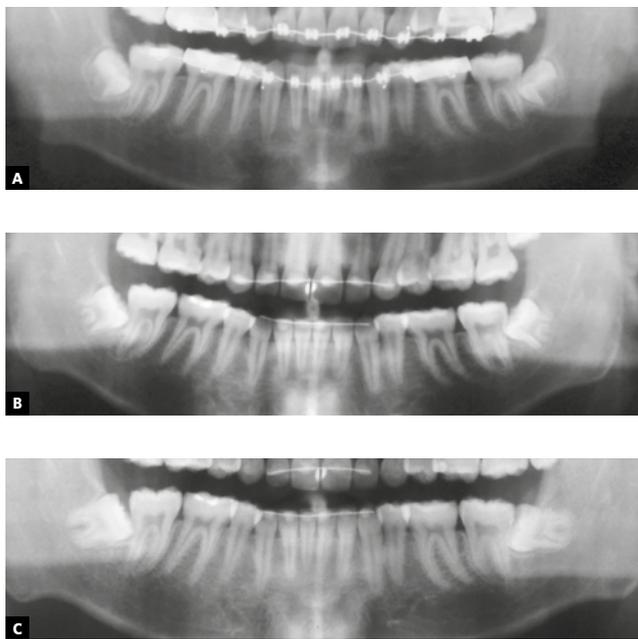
Panoramic radiograph at: A) the end of orthodontic treatment (PR1) and B) follow-up (PR2), of the patient used as a negative control case. Confirmation of the impaction was defined by a third radiograph (C), at 21.3 years.
